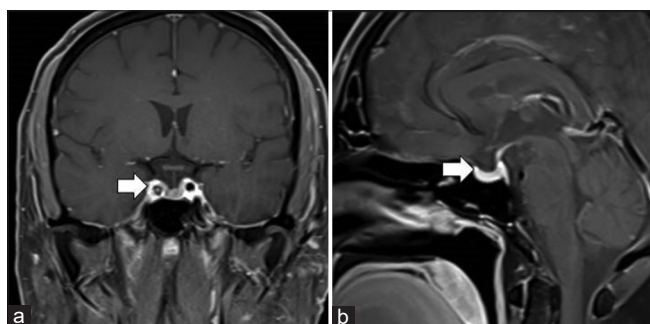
(a) Follow-up post-contrast T1-weighted image showing diminished pituitary size with resolution of left cavernous sinus contrast enhancement, (b) Follow-up post-contrast T1 weighted sagittal image showing resolution of pituitary hyperplasia
